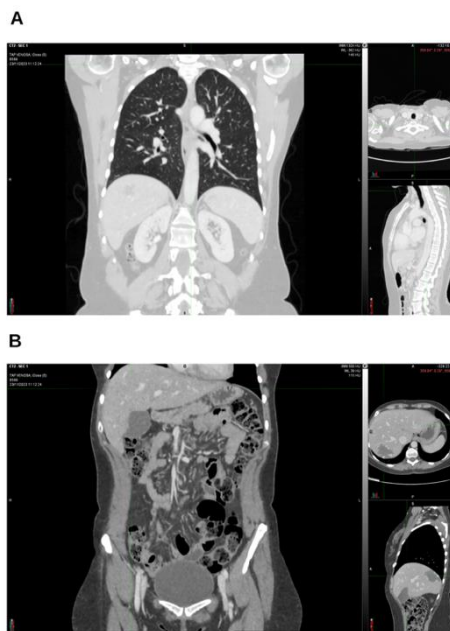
On November 2023, the lung (A), abdomen and pelvis (B) CT scan is still negative.
